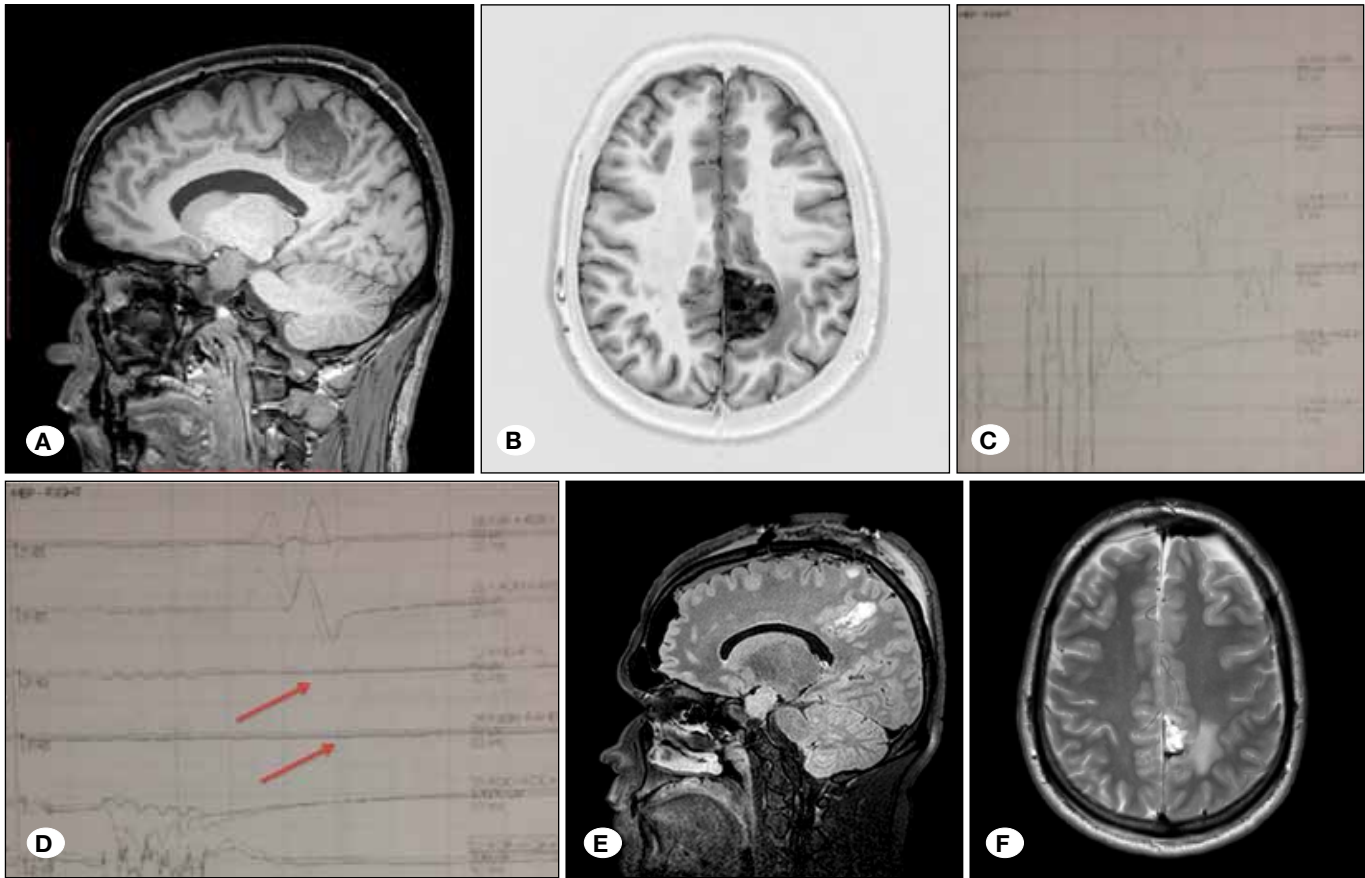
A, B) Enhanced T1-weighted sagittal and axial MRI showing a 3x4x4 cm-sized parasagittal mass lesion in the left frontal lobe. C, D) MEP responses lost in the left lower extremity at the end of the resection. E, F) Postoperative sagittal and axial MRI of the patient.
